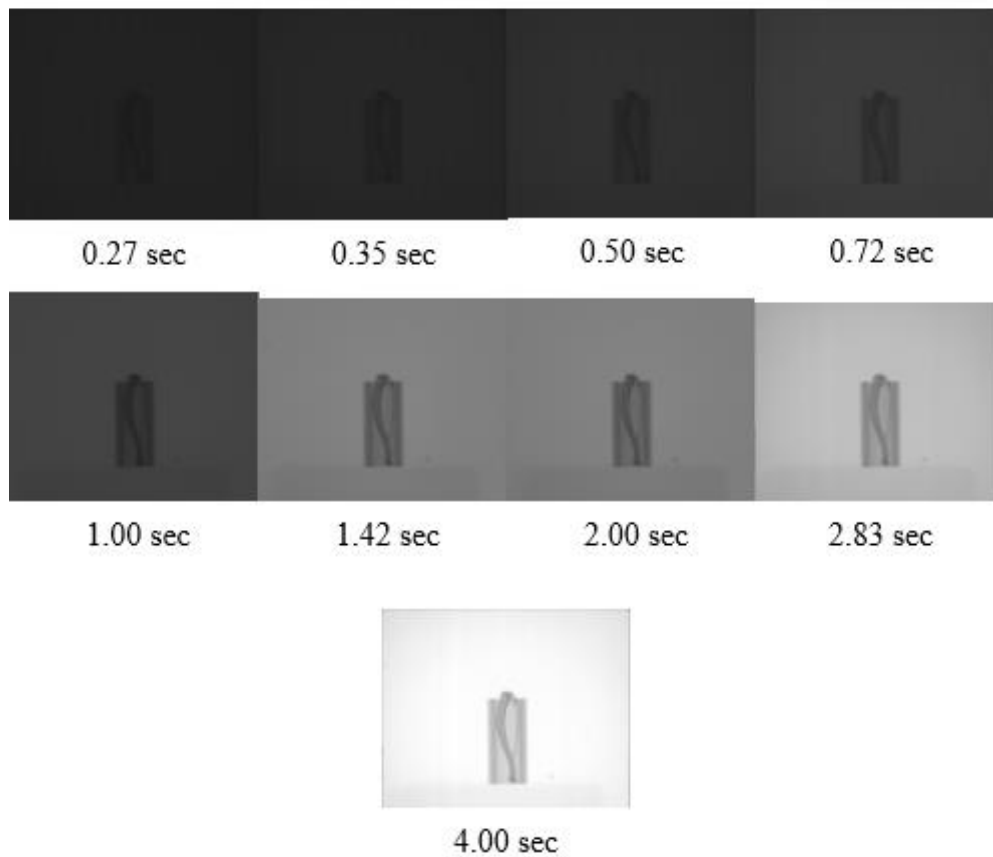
Typical radiographs that were acquired within the X-ray exposure time range of 0.27 sec-4.00 sec, X-ray current of 100 μ A, X-ray tube voltage of 100 kV and FSD of 65 cm.
